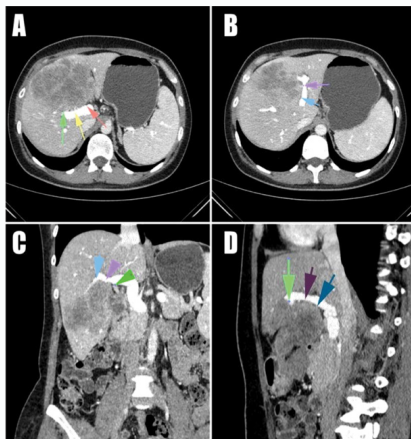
CT scans before the CTx.
